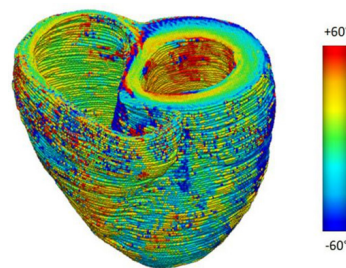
A color map of myofiber helix angles (angles defined with respect to the local circumferential direction) of the LV and RV, derived from an *ex vivo* diffusion tensor MRI of a human heart
